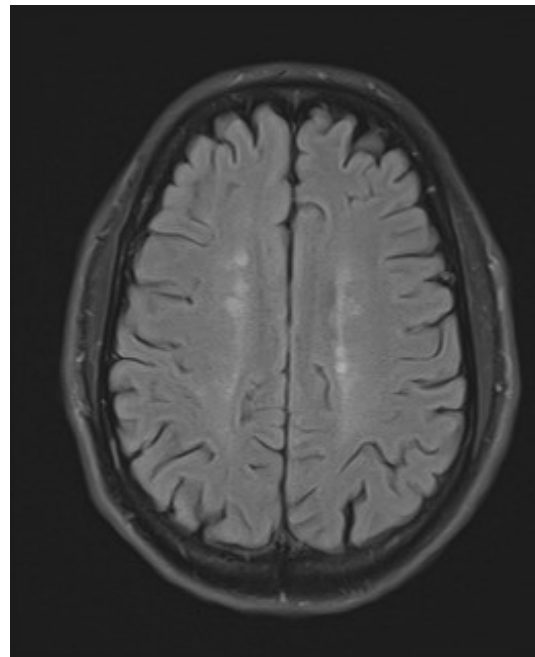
An MRI of the brain with and without contrast showed multiple FLAIR hyperintensities in a pattern concerning for demyelinating disease
